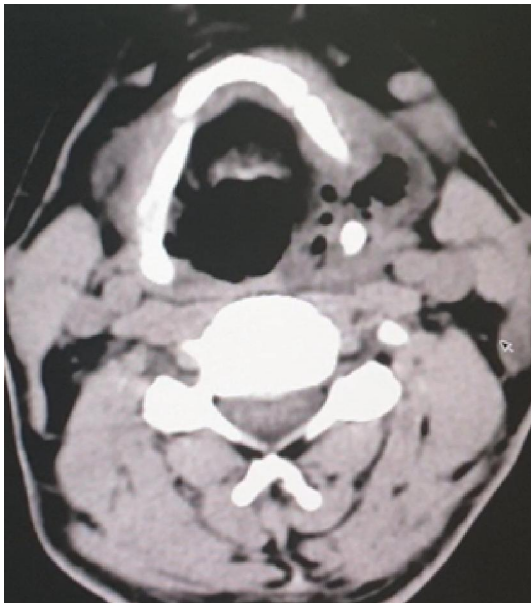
CT neck revealed air at the left parapharyngeal.
